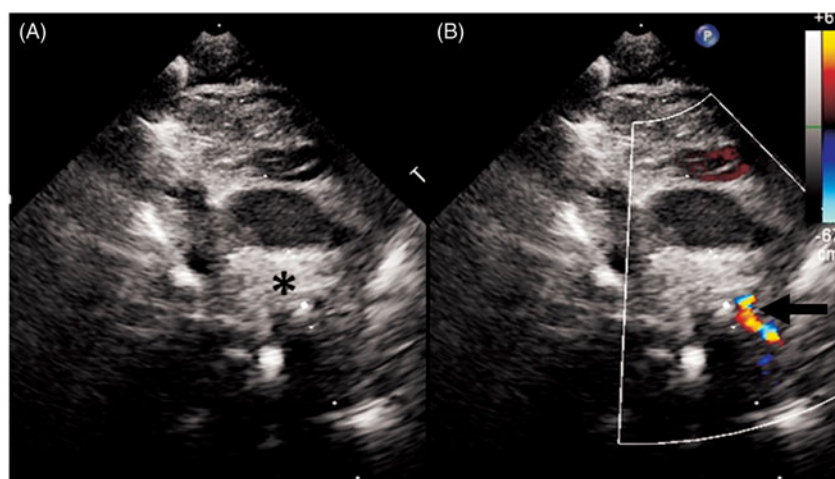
Thrombus in pulmonary artery. Echocardiogram of large thrombus in ductus aneurysm and turbulent flow in left pulmonary artery in patient no 2 who presented on day 3 with infarction of left lung. (A) Two-dimensional short axis shows thrombus in main pulmonary artery (asterisk). (B) Colour flow mapping shows turbulent flow in obstructed left pulmonary artery. Right pulmonary artery was unobstructed.
